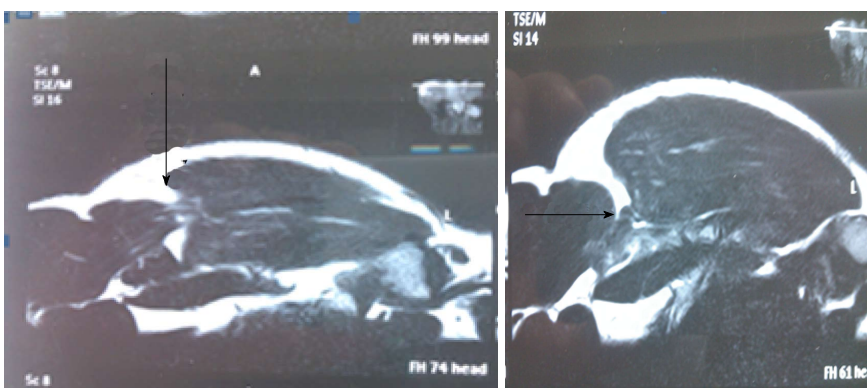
Magnetic resonance imaging report showing near complete tear (arrow) of Pectoralis major muscle.
